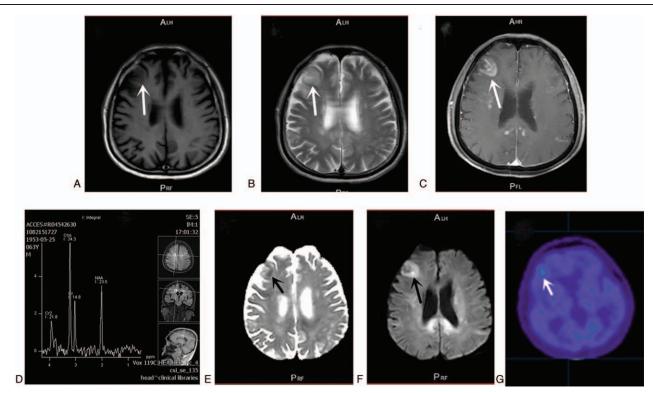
Imaging performance. A and B: The right frontal lobe pointed by the arrow show long T1 and T2 signal shadows. C: As pointed by the arrow, there were patchy T1 enhanced signal shadows in the right frontal lobe and around the midline. D: Cho peak increased, while NAA peak decreased. E and F: As pointed by the arrow, ADC showed low-value changes and DWI high signal changes. G: Radioactive accumulation in the right frontal lobe as pointed by the arrow. DWI = diffusion-weighted imaging, NAA = N-acetylaspartate.
